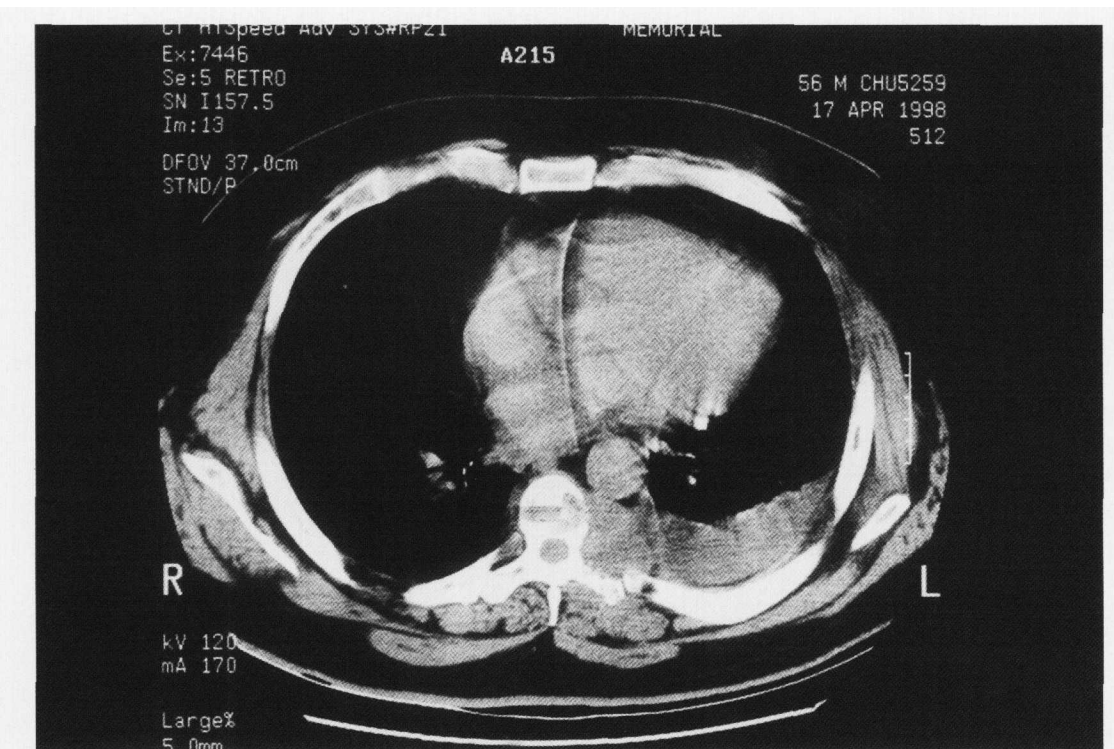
CT Scan: Bony destruction of the left side of the vertebral body and posterior arch of D7, with evidence of involvement of cord.
